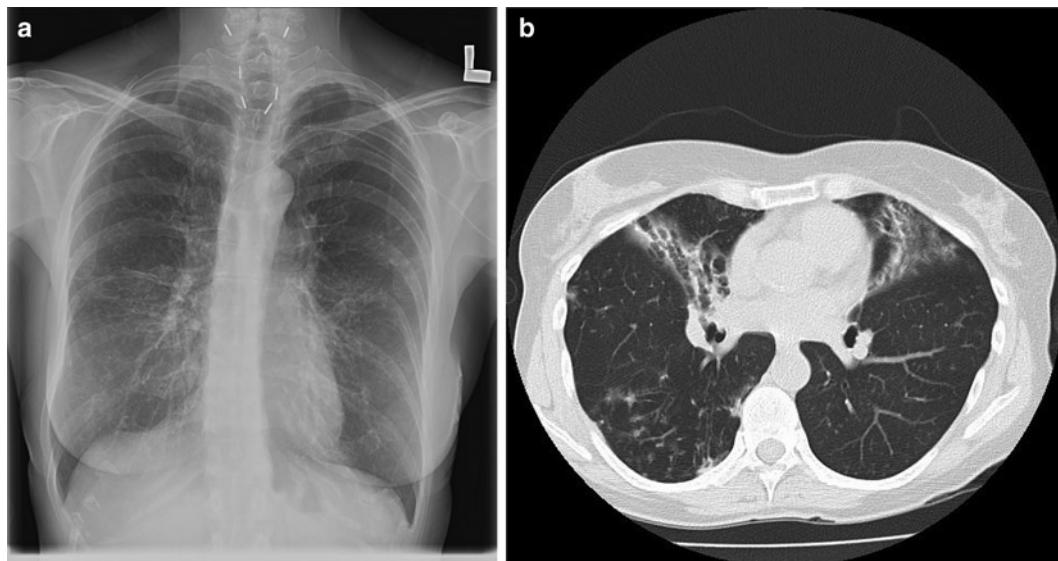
(a) Chest X-ray and (b) chest CT scan of a patient with severe bilateral bronchiectasis predominately affecting the lower lobes. There is extensive bronchial thickening and dilation with evidence of mucoid impaction. The left lower lobe is atelectatic. Oxygen tubing can be seen in the chest X-ray. This patient has a ciliary dysmotility syndrome of unknown etiology. A peripheral central infusion cannula and clips from previous thyroid surgery can be seen on the chest X-ray.
